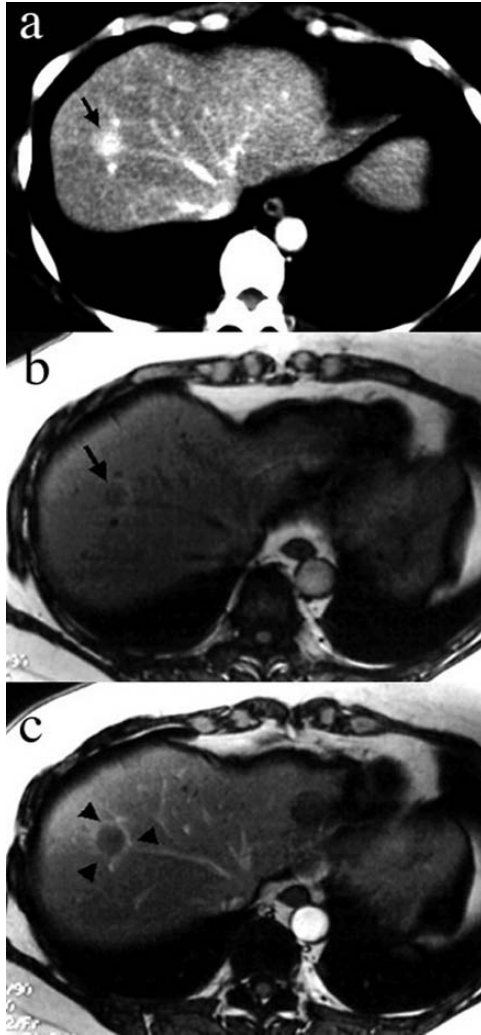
Liver metastasis from colonic cancer in a 52-year-old female: Ring enhancement. Contrast-enhanced CT exhibits a well-enhancing mass in S8, mimicking liver hemangioma (a, arrow). The T1W-GRE image exhibits a hypointense mass (b, arrow). After SPIO administration, positive ring enhancement is noted around the tumor (c, arrowheads).
